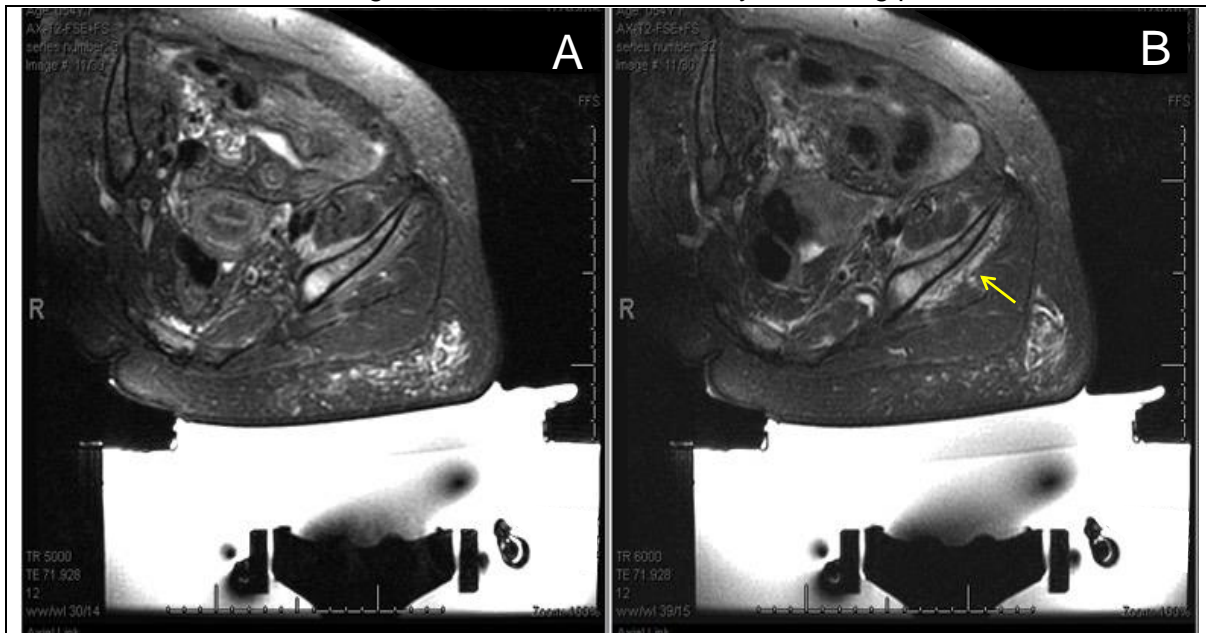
A comparison of T2w MR images (A) before and (B) immediately after MRgFUS treatment, showing edema (arrow) superficial to the treated left iliac bone metastasis.
